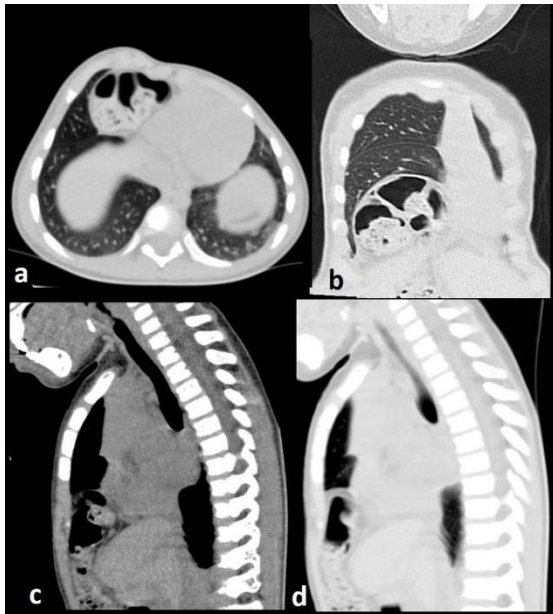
CT thorax: a) axial lung window, b) coronal lung window, c) sagittal soft tissue window, d) sagittal lung window, which demonstrates herniation of bowel loop through a defect at the anterior medial aspect of the right hemidiaphragm into the lower right lung, consistent with a congenital diaphragmatic hernia (Morgagni type).
